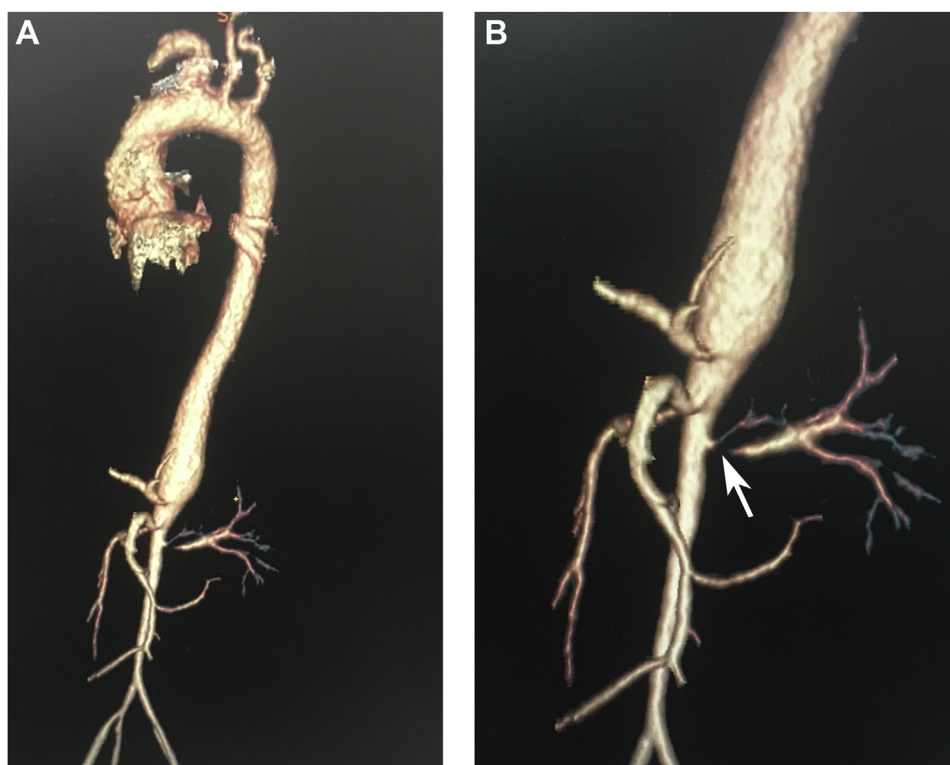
(A) CT angiography of the aorta showed arterial wall thickening of bilateral common and internal carotid arteries, the aneurysms from celiac trunk up to infrarenal aorta, the long stenosis from the infrarenal aorta up to the iliac arteries. (B) Left renal artery with severe stenosis at the origin (white arrow), right renal artery with mild stenosis.
